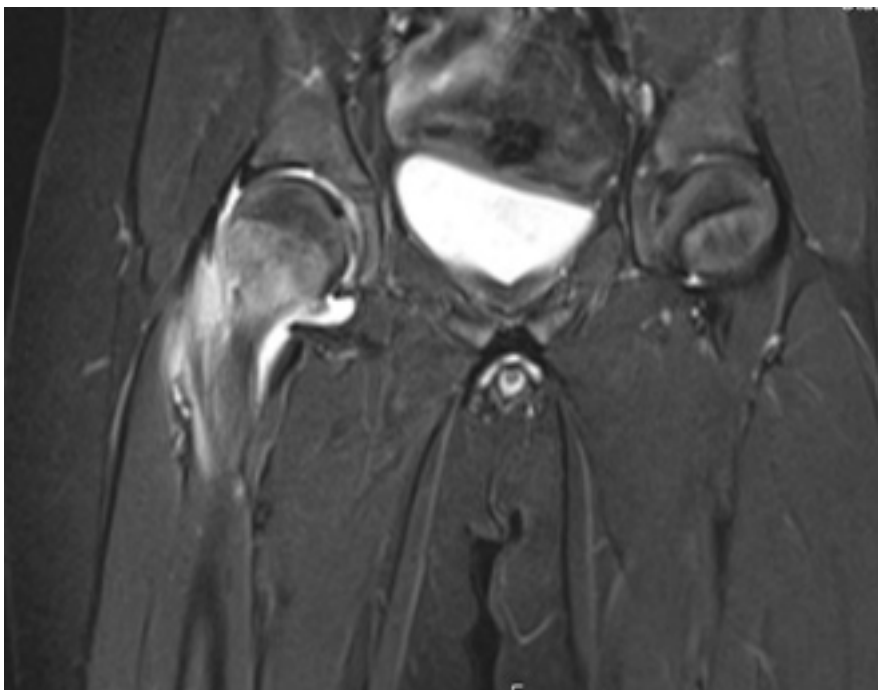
Contrast coronal CT of the upper femur
